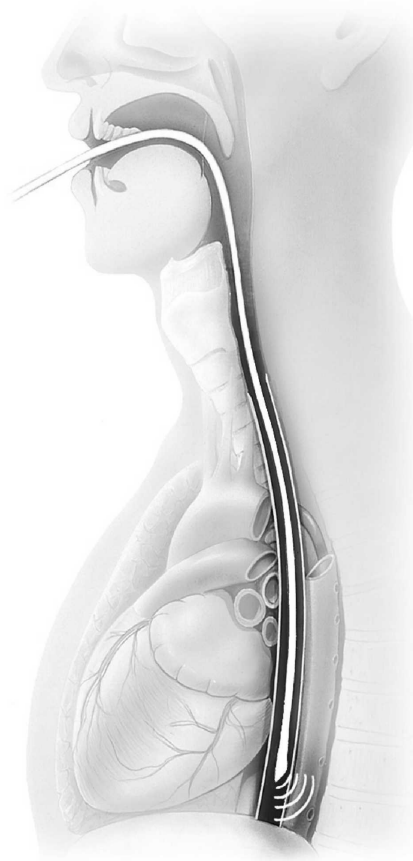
Correct positioning of the oesophageal Doppler probe.
